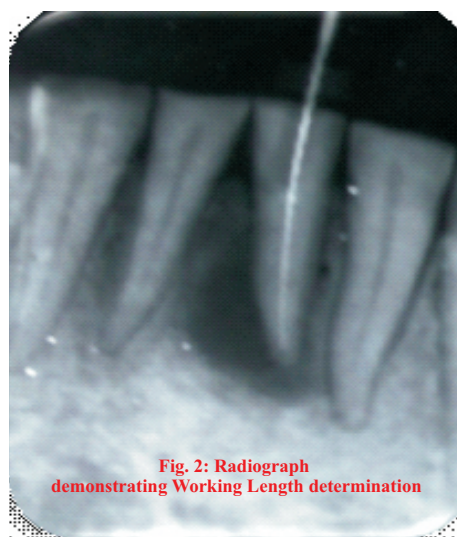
Radiograph demonstrating Working Length determination
